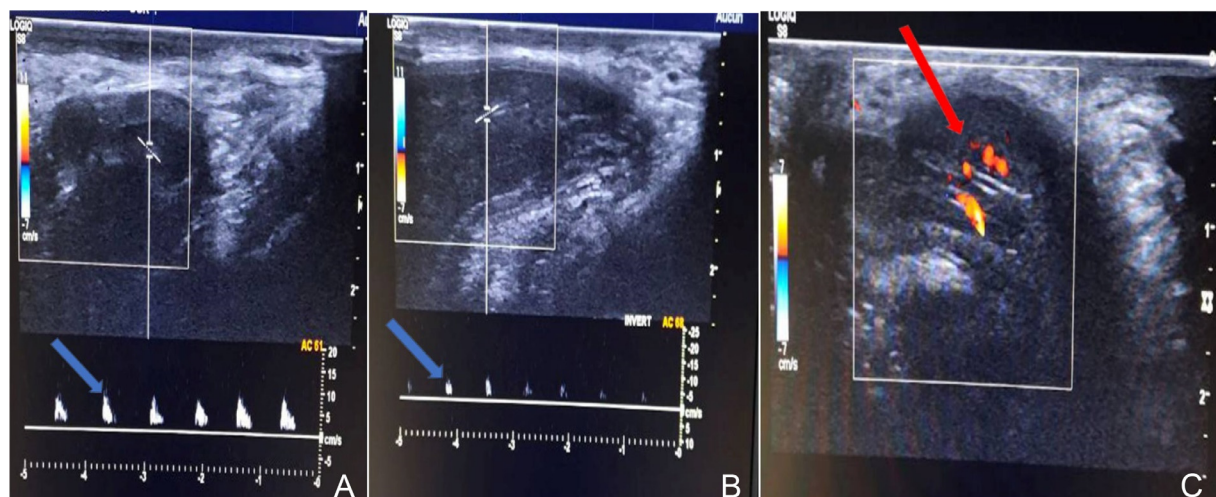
Ultrasound with Color Doppler control shows a permeabilization of the left cavernous artery (A and B) (blue arrow) and no recurrence of the fistula (C) (red arrow).
